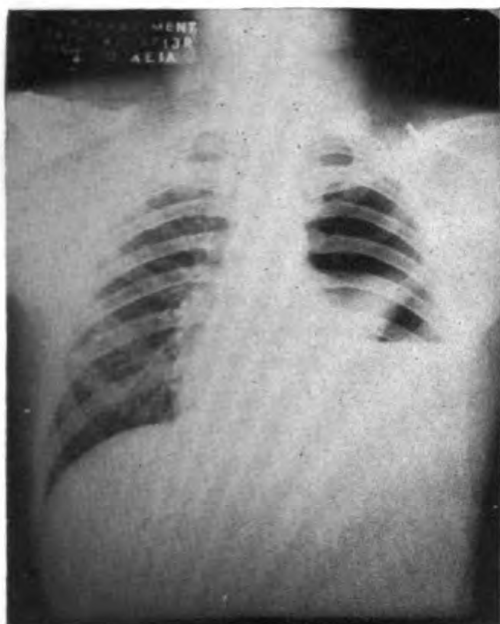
Case 2. Preoperative x-ray following paracentesis of the left chest showing complete atelectasis of the exposed portion of the lung, fluid, and pneumothorax.
